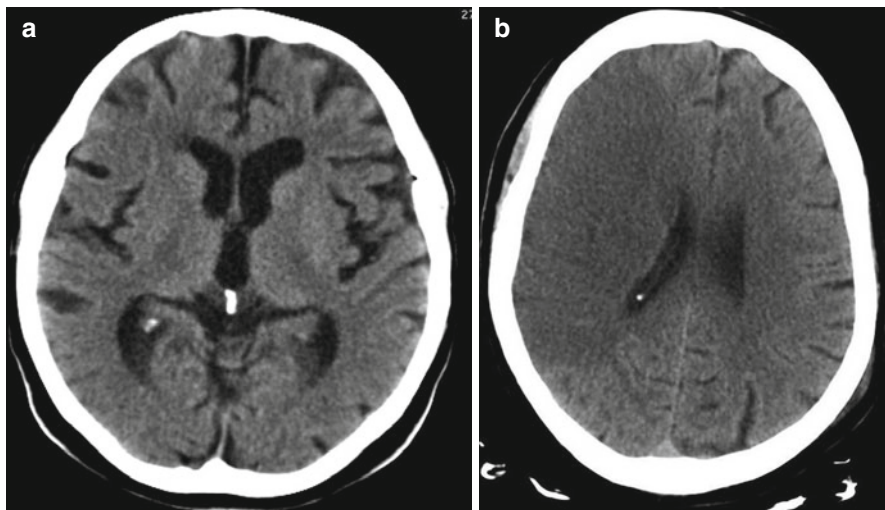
Unenhanced CT scans. (a) Normal brain. (b) Ischemic infarction of the right hemisphere
